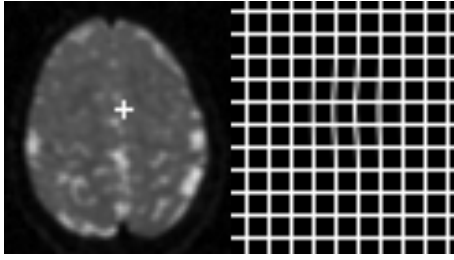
Left: MR image used for local, nonrigid, deformation experiment. The white cross close to the center of the image indicates the location of the basis function. Right: local deformation computed using the compactly supported basis function. The location coinciding with the center of the basis function is moved one pixel to the right.
